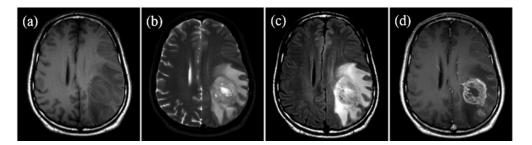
(a) T1w, (b) T2w, (c) FLAIR and (d) T1w+Gd images of patient with high-grade glioma [43].
